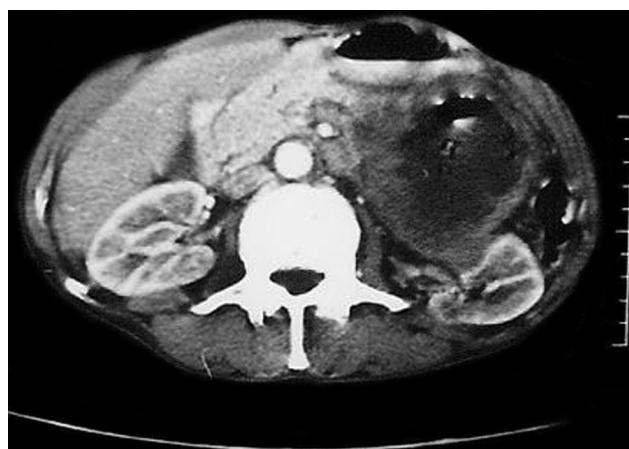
CT scan abdomen showing hydatid cyst in pancreatic tail region with jagged margins and no daughter cysts.
